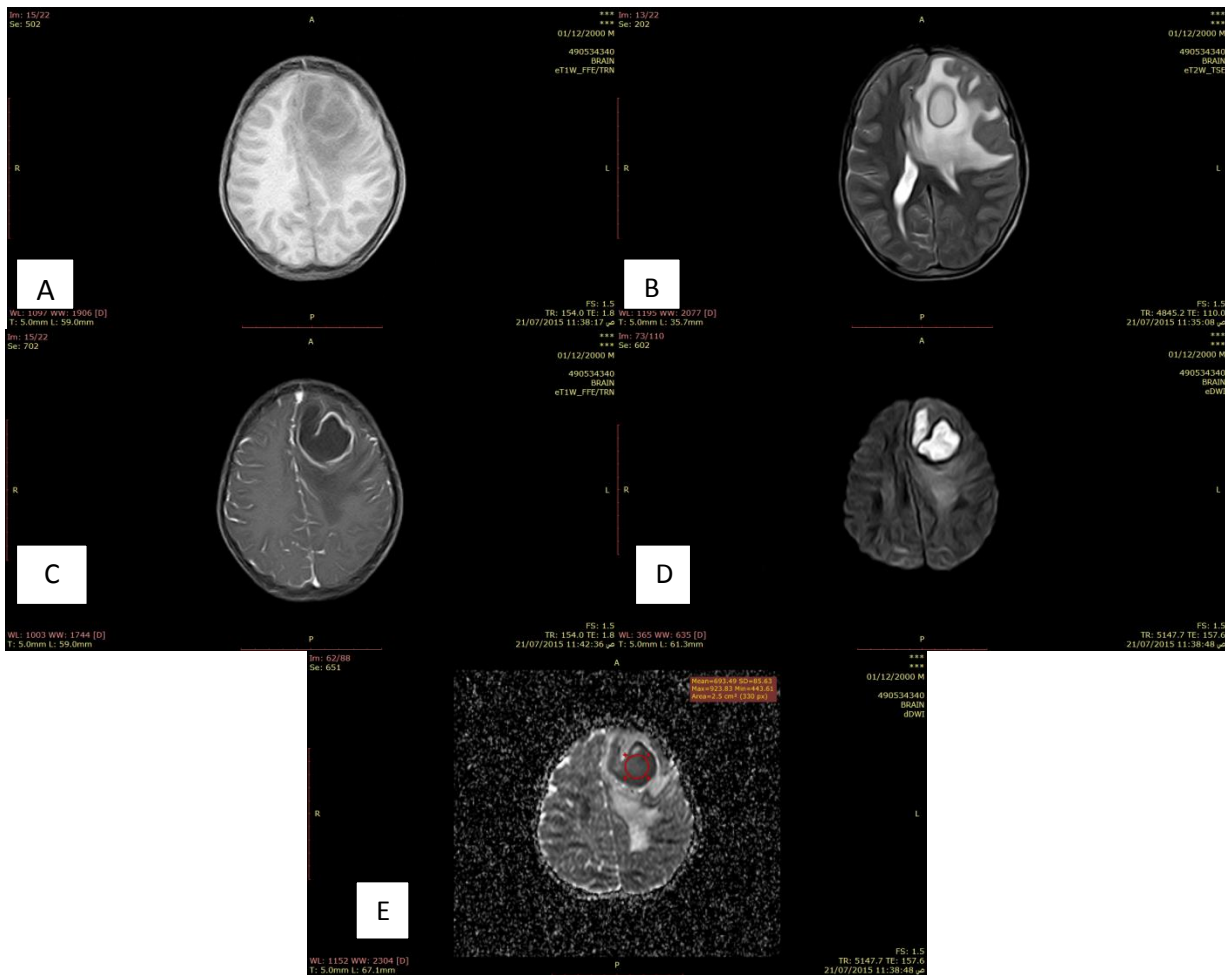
15-year-old male patient with left parietal mass (A. T1 axial; B.T2 axial; C.T1 axial postcontrast; D. DWI; E. ADC) showing ring enhancement and restricted diffusion with maximal ADC values (0.92 x10-3) and biopsy-proven abscess.
